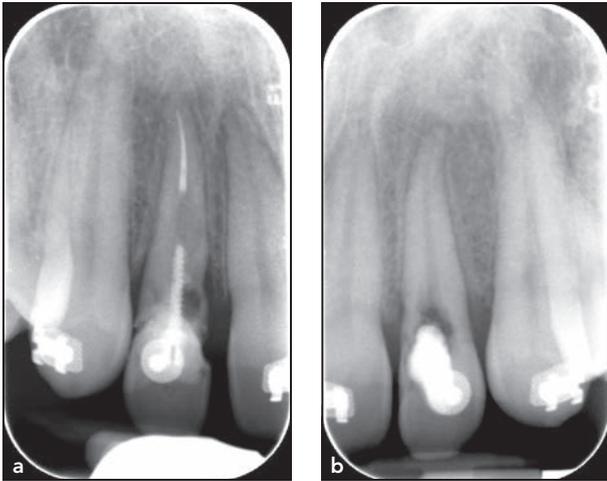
Pretreatment intraoral periapical radiographs of (a) tooth 12 and (b) tooth 22.
